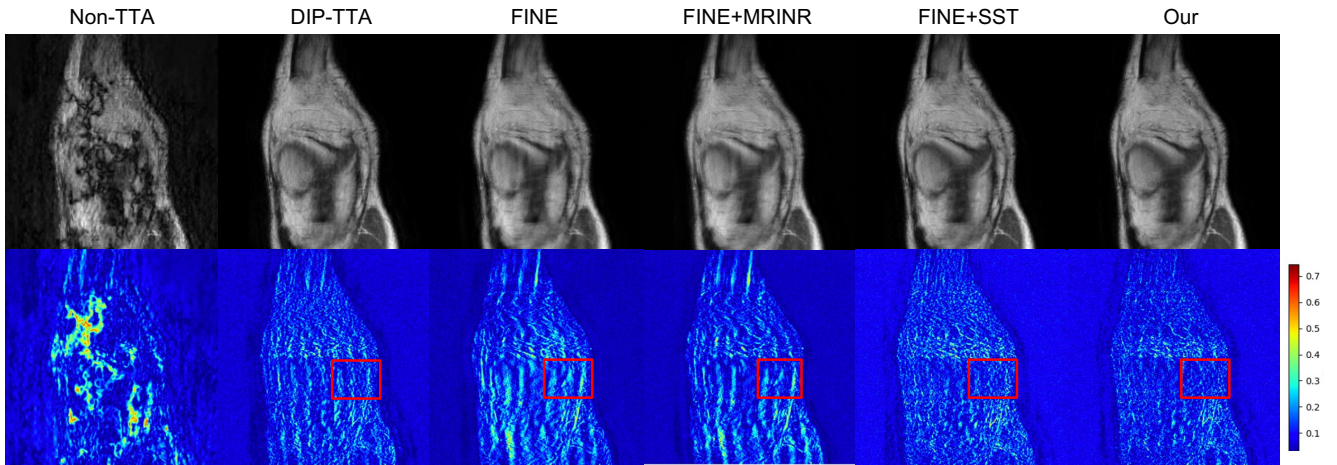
Comparison of different frameworks in Unet under dataset shift (Stanford to fastMRI) using the FINE method. The first row shows reconstructed MRI images, while the second row presents residual maps between reconstructions and full-sampled MRI.
